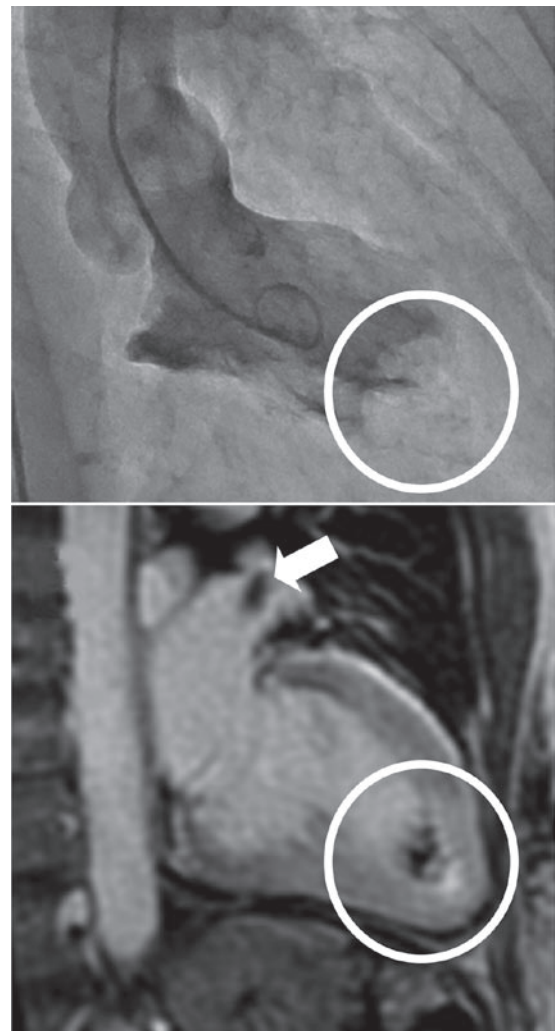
Top, Left ventricular apical thrombus (circle) as seen by ventriculography (day 10 of most recent admission). Bottom, Left ventricular apical thrombus (circle) and left atrial appendage thrombus (arrow) as seen on cardiac magnetic resonance imaging (day 12) with use of a gradient echo inversion recovery sequence 2 minutes after gadolinium-diethylenetriaminepentaacetic acid injection (0.2 mmol/kg; inversion recovery time, 350 ms).
